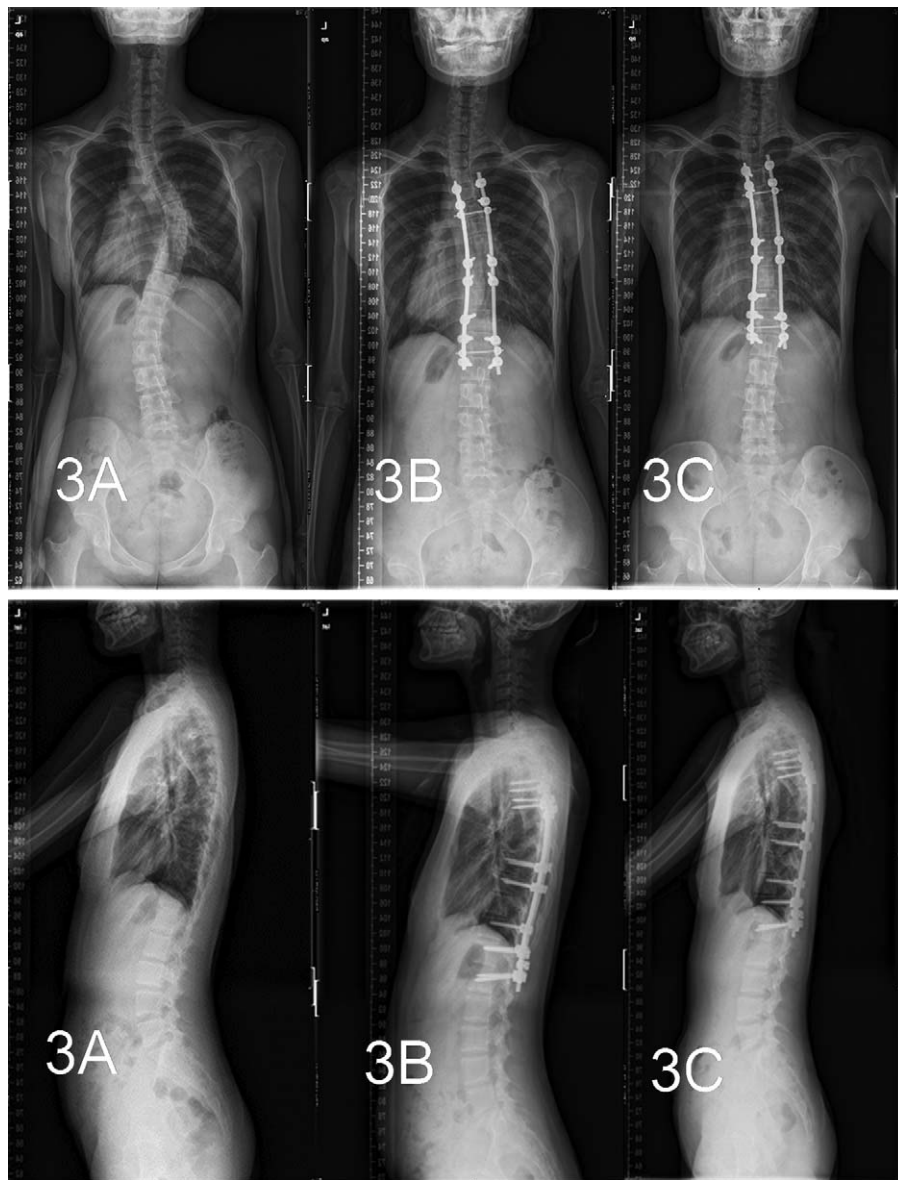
T4 was selected as the upper instrumented vertebrae, preoperative (A), immediately after surgery(B), and final follow-up (C) x-ray films.
